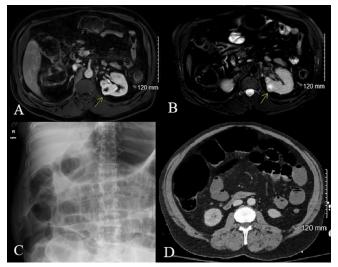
MR scan of abdomen, axial plane, demonstrating a 4.2 x 2.4 x 2.8 cm left upper pole exophytic contrastenhancing renal mass (A) with central T2 hyperintensity (B) concerning for renal cell neoplasm, possibly clear cell subtype. Abdominal X-ray demonstrating distended stomach and air-filled loops of small and large bowel (C), CT scan of abdomen demonstrating diffusely distended colon (D).
